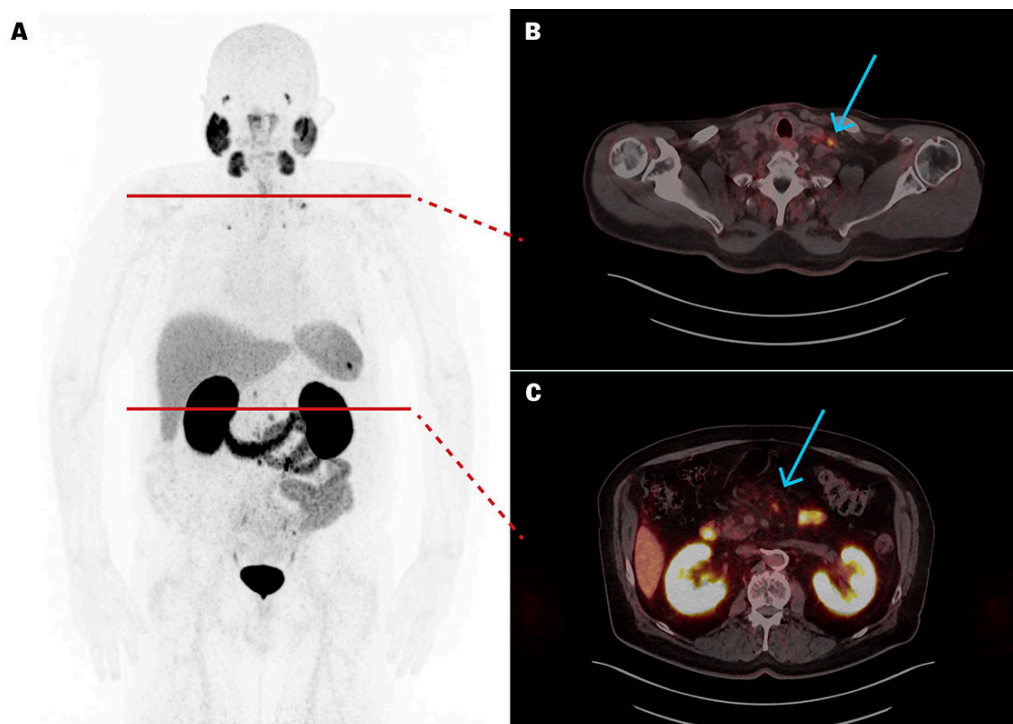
[^{68}Ga]PSMA-11 PET/CT after five treatments with [^{177}Lu]PSMA-617 showed a significant reduction in the size of metastases in the lymph nodes in the abdomen, chest and neck.
